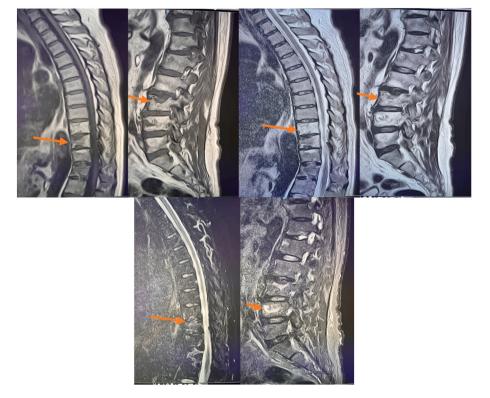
Thoracic and lumbar Nuclear Magnetic Resonance image in T1, T2 and Short Tau Inversion Recovery sequences, still with osteolytic lesions in T9-L5 vertebral bodies in the process of remission.
